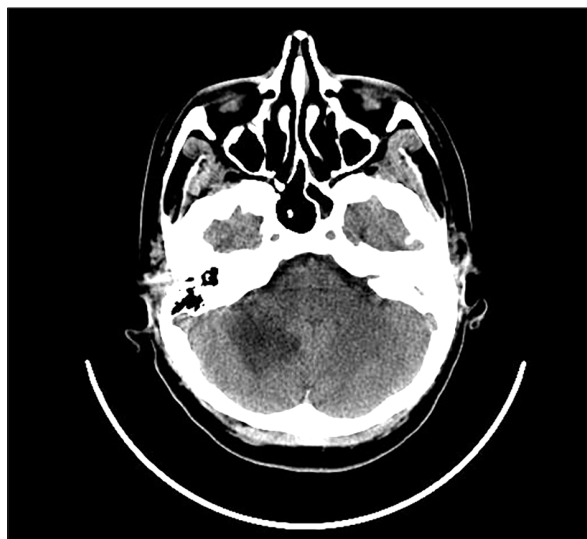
CT scan: in the right cerebellar hemisphere – hypodense area, without enhancement, 37/33mm.
